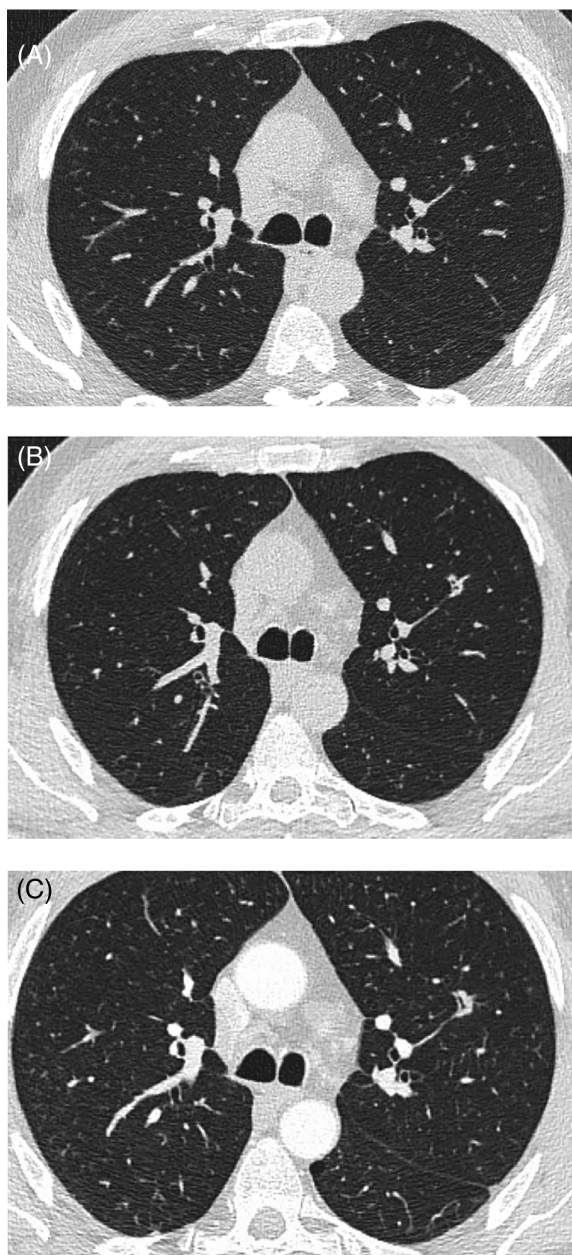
(A) Baseline low-dose computed tomography (LDCT) in a 70-year-old former smoker showing left upper lobe nodule (PanCan (Pan Canadian Early Detection of Lung Cancer study) risk score: 5.9%). (B) 12-Month follow-up LDCT showing some change in the left upper lobe nodule. (C) 15-Month follow-up LDCT showing further change in the left upper lobe nodule, biopsy and resection revealed T1bN0M0 (IA2) adenocarcinoma.
